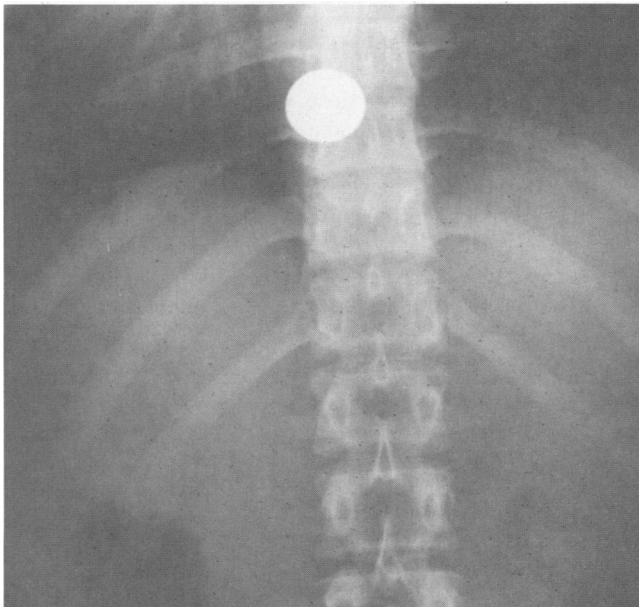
The radiograph shows a quarter lodged at the gastroesophageal junction in patient 1.
